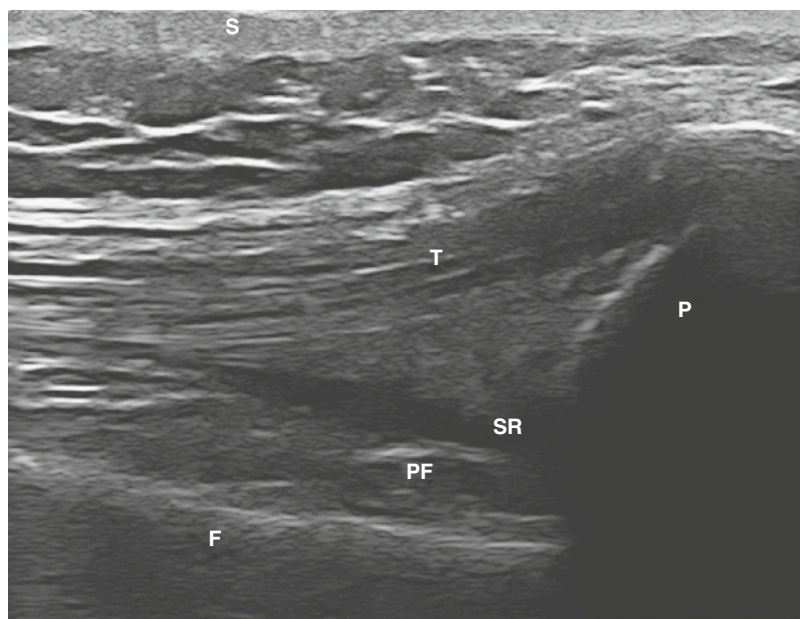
SUPRAPATELLAR RECESS. Ultrasound shows the suprapatellar recess, which contains a minimal amount of fluid. F, femur; P, patella; PF, peribursal fat; S, skin; SR, suprapatellar recess; T, quadriceps tendon.
